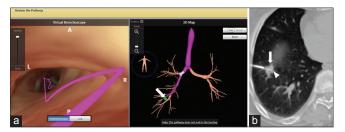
Planning electromagnetic navigational bronchoscopy (ENB) for a slowly growing nodule in the right lower lobe (white arrow). Images show the virtual bronchoscopic and 3D maps (a) to help navigate the bronchoscope close to the right lower lobe nodule and facilitate biopsy. These maps are created using the CT data set obtained before the procedure. A CT-guided biopsy was subsequently performed as the ENB biopsy was non-diagnostic. The axial CT image (b) obtained during the procedure with the needle (white arrowhead) deployed in the center of the nodule (white arrows) before obtaining the sample. The CT biopsy sample showed non- small cell cancer.
